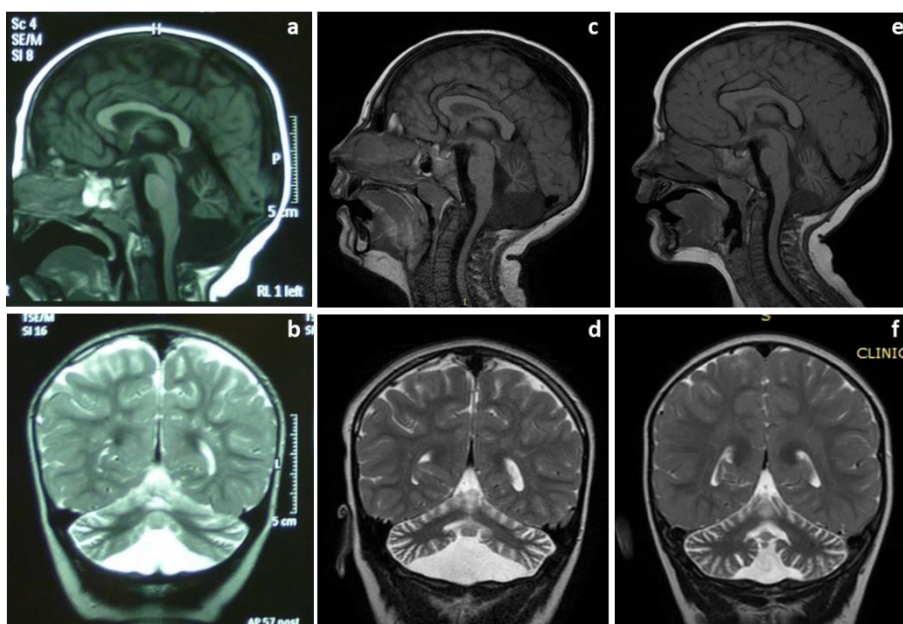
Brain MRI of the two brothers. a-b: Sagittal T1- and Coronal T2- weighted images of index patient at the age of 1.5 years, showing global cerebellar hypoplasia and enlarged interfolial spaces. c-d: Sagittal T1- and Coronal T2-weighted images of the same child at the age of 6.5 years, suggestive of stable cerebellar atrophy. e-f: Sagittal T1- and Coronal T2- weighted images of the younger brother at the age of 1.5 years, revealing marked enlargement of cerebellar interfolial spaces.
